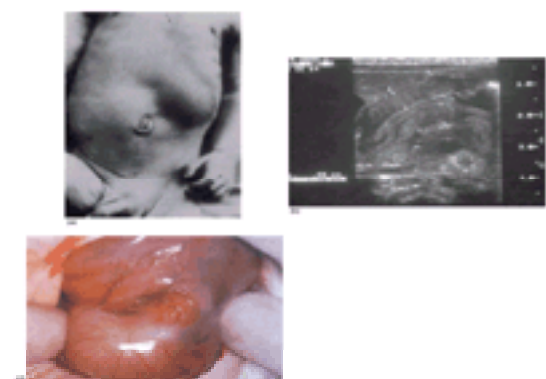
(a) Pyloric stenosis: visible peristalsis in a thin boy. (b) Pyloric stenosis: the elongated thick pylorus is clearly seen on this longitudinal ultrasound. The muscle
